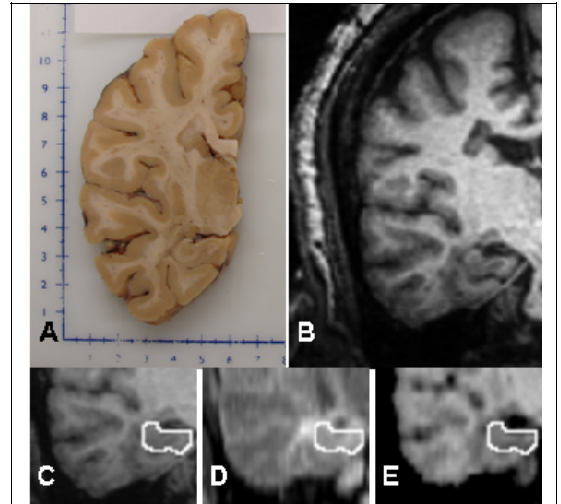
(a) Fixed tissue slice and (b) corresponding MPRAGE slice after image-to-tissue registration; hippocampal tracing superimposed on (c) MPRAGE, (d) FLAIR, and (e) MTR images
